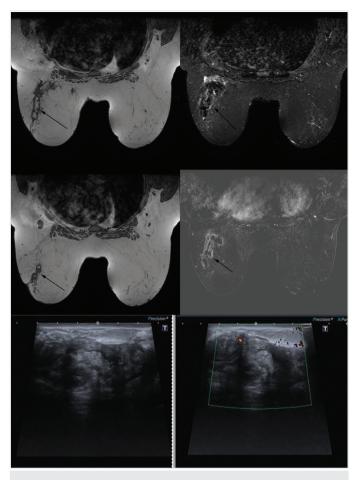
A 39-year-old patient's postoperative 4<sup>th</sup> year radiological ultrasonography images following breast reduction. Right breast shows hypoechoic subcutaneous cysts in the outer peri areolar area (left). Left breast image reveals outer quadrant parenchymal superficial hypoechoic and hyperechoic cysts (right)
